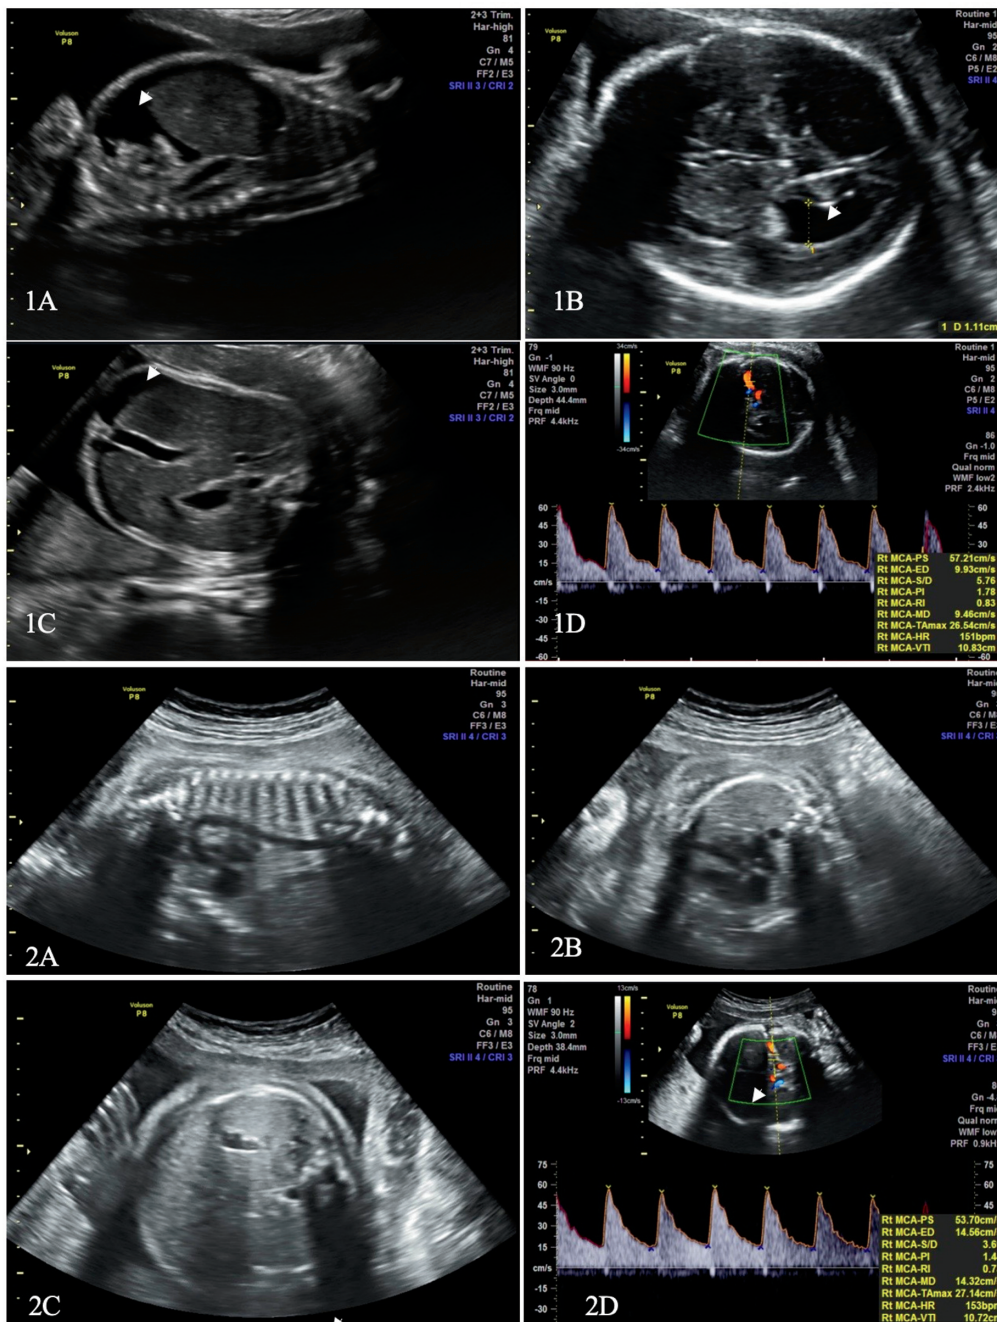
Initial presentation on hospital day (HD)1 with pleural effusion (A, arrow), ventriculomegaly (B, arrow), enlarging fetal ascites (C), and elevated middle cerebral artery (MCA) Dopplers (D), compared with resolution of pleural effusion (A), ventriculomegaly (B), fetal ascites (C), and normalized MCA (D) Dopplers on HD8.
